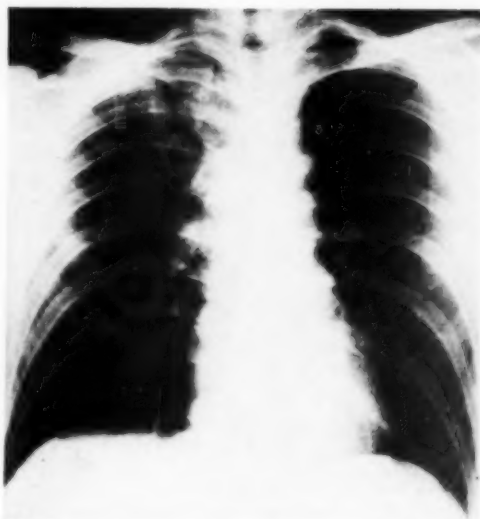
Roentgenogram taken one month after D. The abscess evacuated spontaneously into a bronchus and a cavity now is seen. Following this there was a gradual decrease in the size of the cavity and the lesion healed, leaving only a few fibrous strands.
